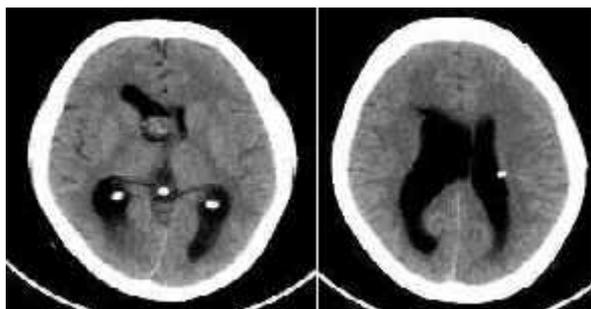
(a,b) Plain CT Brain Axial
